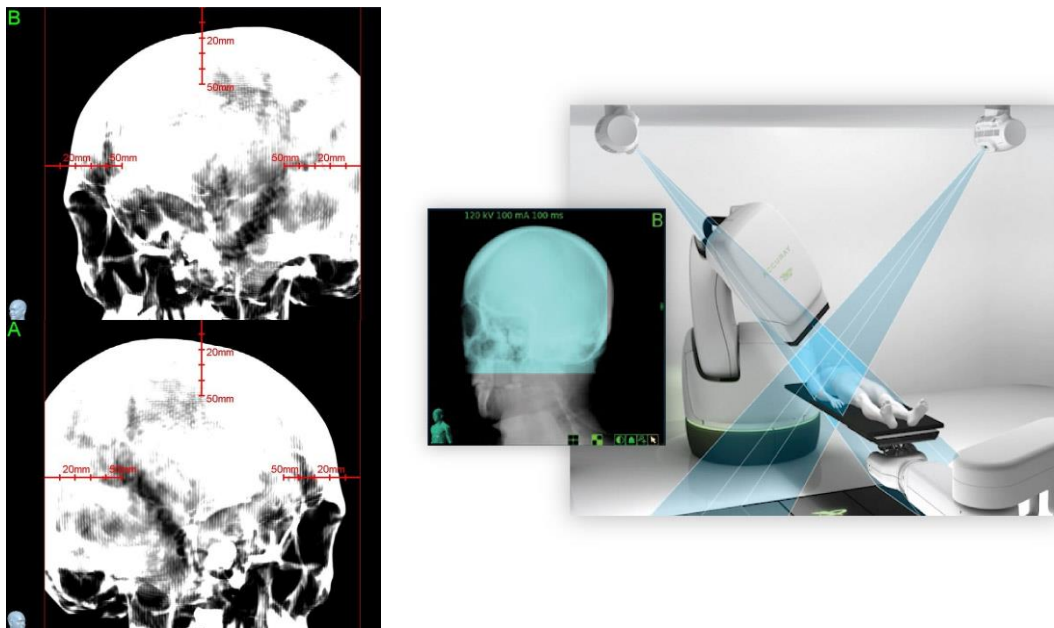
Example of DRR images for a brain treatment (left). These orthogonal images generated in the TPS are later used to position the patient through registration with the X-ray images from the in-room kV system (right, <https://www.accuray.com/wp-content/uploads/frameless-stereotactic-targeting-srs.jpg>).
